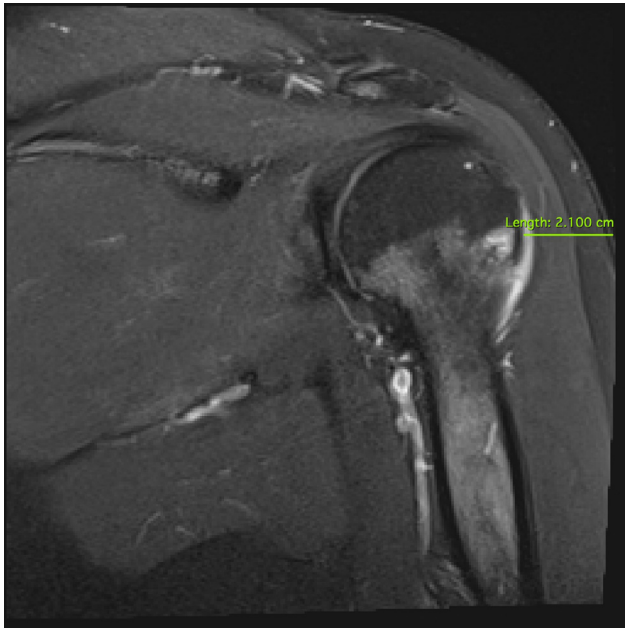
Case 2. Short tau inversion recovery (STIR) coronal MRI sequence demonstrating focal humeral head edema. Green line measures the distance between the humeral head and skin surface.
